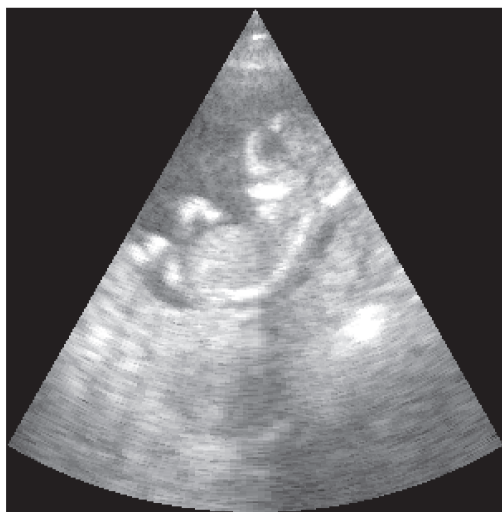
Ultrasound image (2.5 MHz) of a 14-week old foetus.
